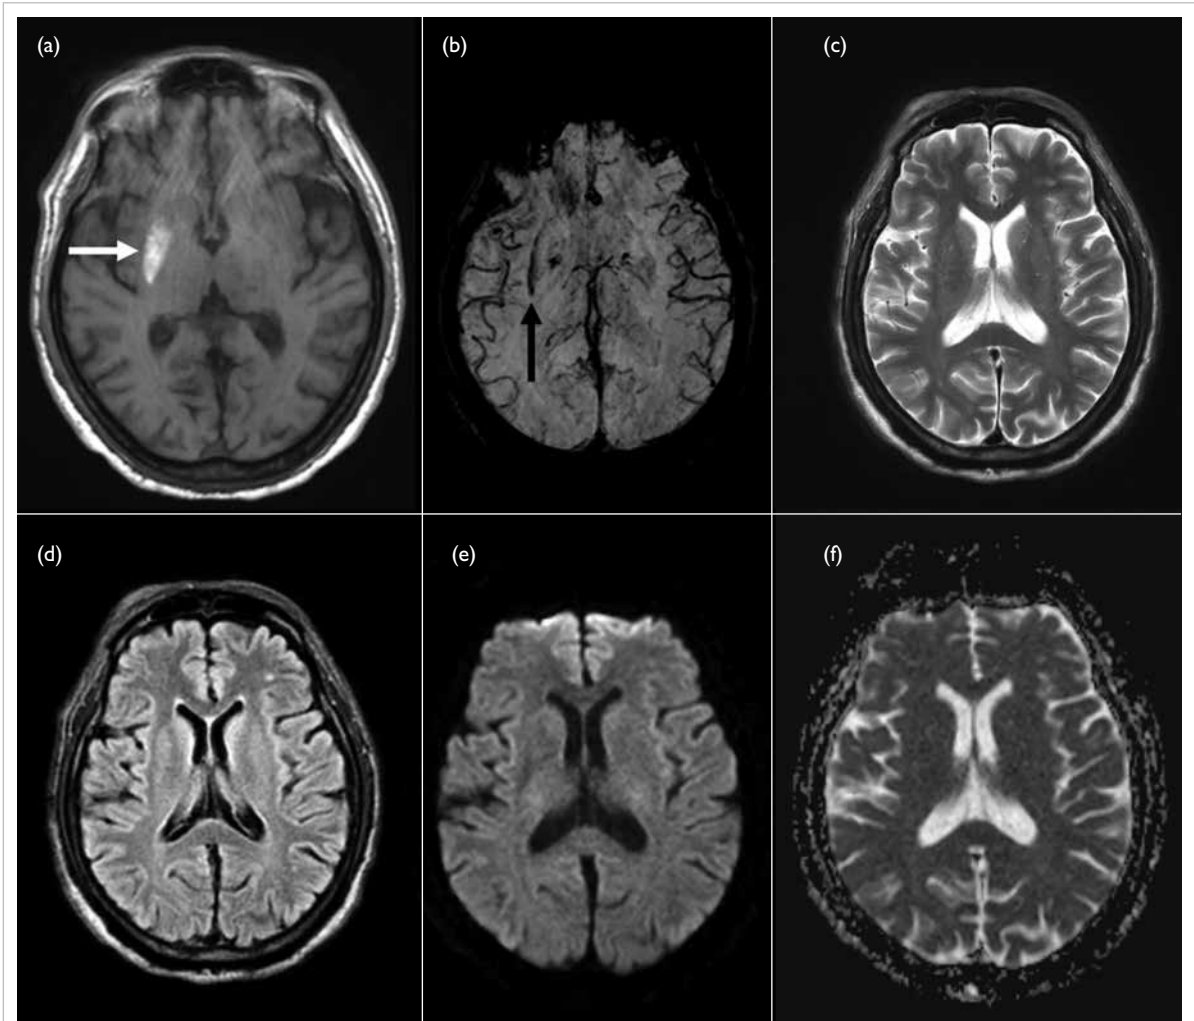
Case 1. Non-contrast magnetic resonance imaging of the brain with non-ketotic hyperglycaemic hemichorea. (a) T1-weighted sequence showing hyperintense signal in right putamen (white arrow). (b) Susceptibility weighted imaging showing rim of susceptibility signal in right putamen (black arrow). (c) T2-weighted sequence and (d) T2-weighted fluid-attenuated inversion recovery sequence showing symmetrical signals in bilateral basal ganglia. (e) Diffusion-weighted imaging and (f) apparent diffusion coefficient map showing no restricted diffusion
